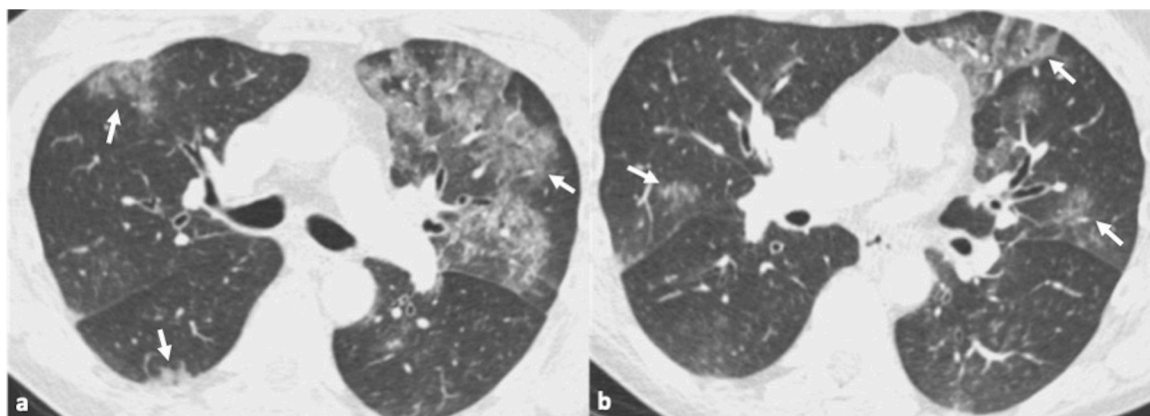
45-year-old male patient with confirmed influenza pneumonia. 2a, b. Axial CT images show multifocal patchy ground glass opacities (arrows).
